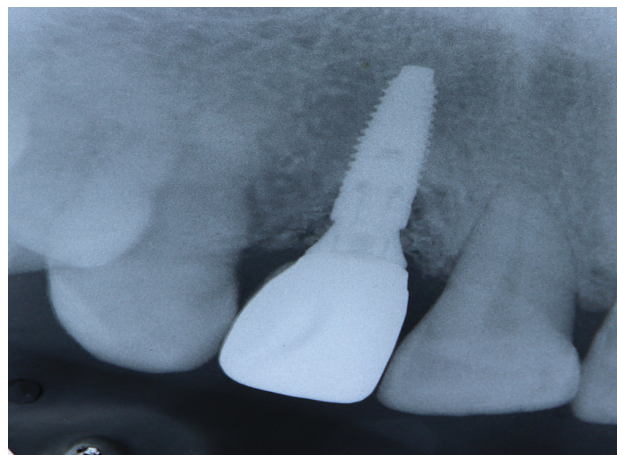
Intra-oral periapical radiograph showing final prosthesis.
